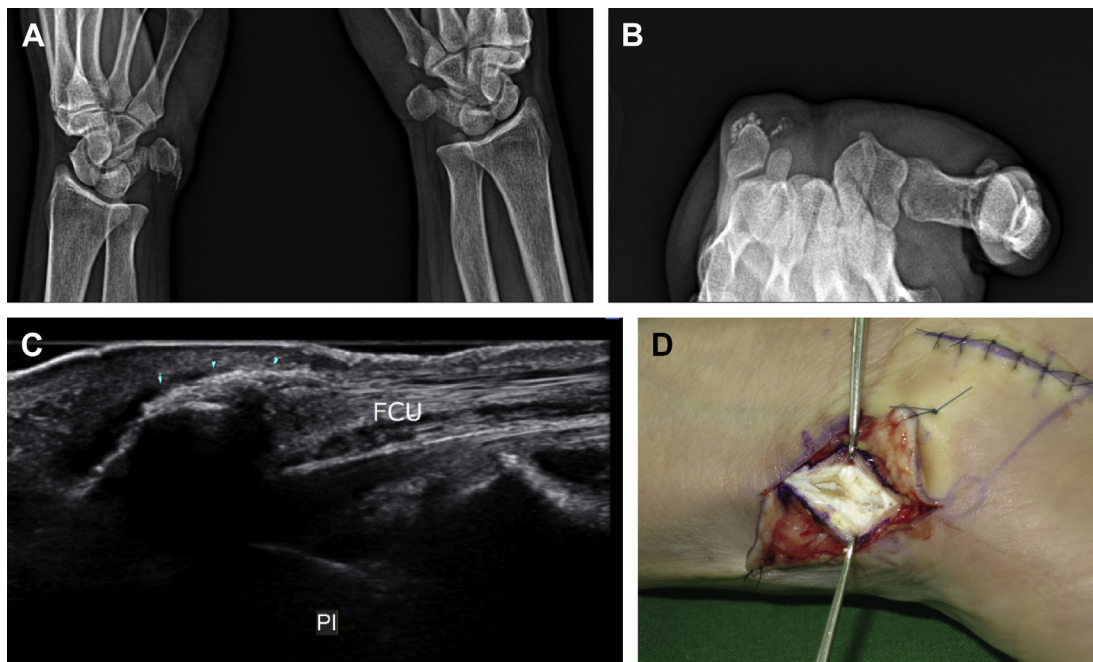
(A–C) A 56-year-old female patient already had several corticosteroid injections because of severe ulnar-side pain. On pisiform bone view and carpal tunnel view, ultrasonography showed marked calcific deposits around the FCU and pisiform (PI). (D) Intraoperative view of calcification.
